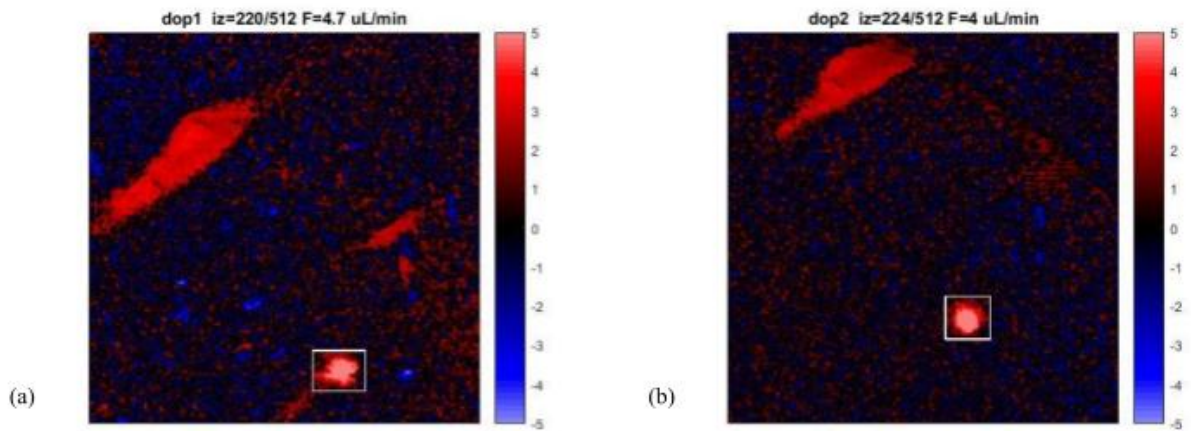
Changes in the arterial blood flow after seizure activity (experiment ID: 180328). (a) Doppler OCT image before pilocarpine injection. ROI at a depth of 770 μm . Cerebral blood flow 4.7 $\mu\text{L}/\text{min}$. (b) Doppler OCT image 51 min after pilocarpine administration. ROI at pixel depth of 224. Cerebral blood flow 4 $\mu\text{L}/\text{min}$.
